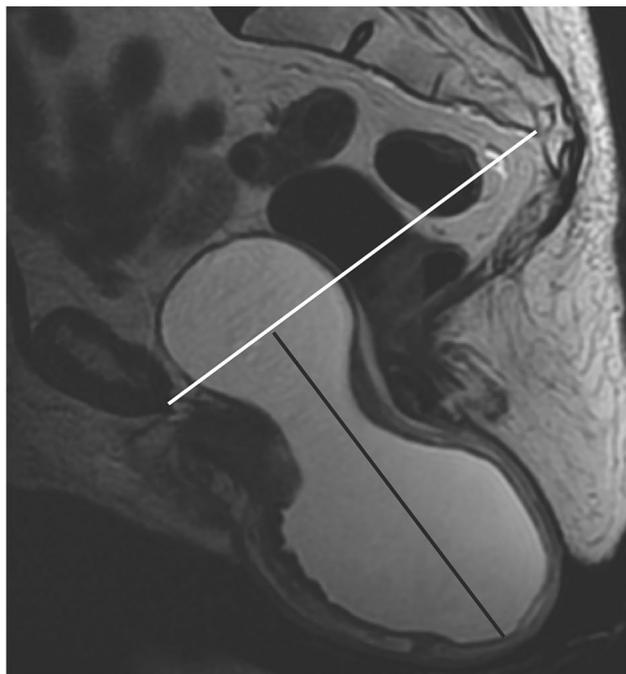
Severe cystocele. A 73-year-old patient with clinically apparent cystocele presented for pelvic MRI to evaluate the cystocele and for multi-compartment involvement. T2-weighted image shows a severe cystocele extending below the pubococcygeal line (white line) for approximately 8 cm (black line). The uterus has been removed and the rectum does not demonstrate pelvic descent
